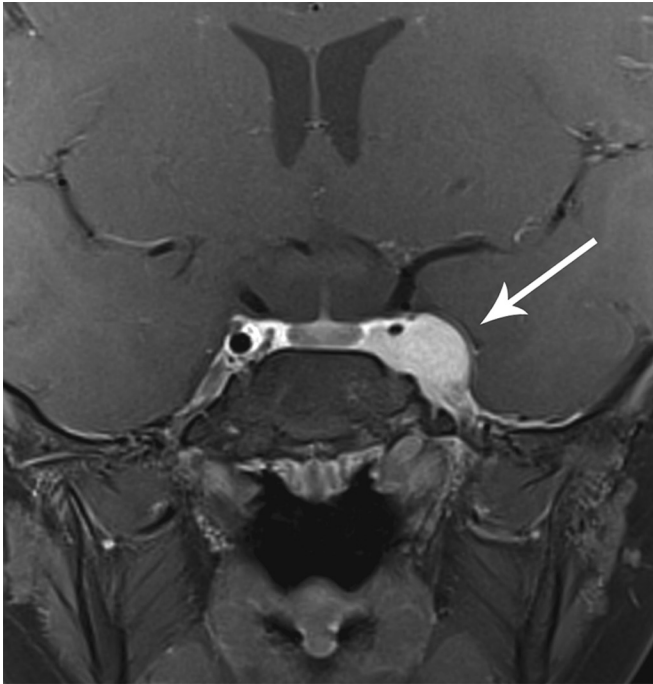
Coronal T1 contrast-enhanced magnetic resonance image obtained at presentation in a child with intracranial extension from a pterygopalatine fossa rhabdomyosarcoma.
